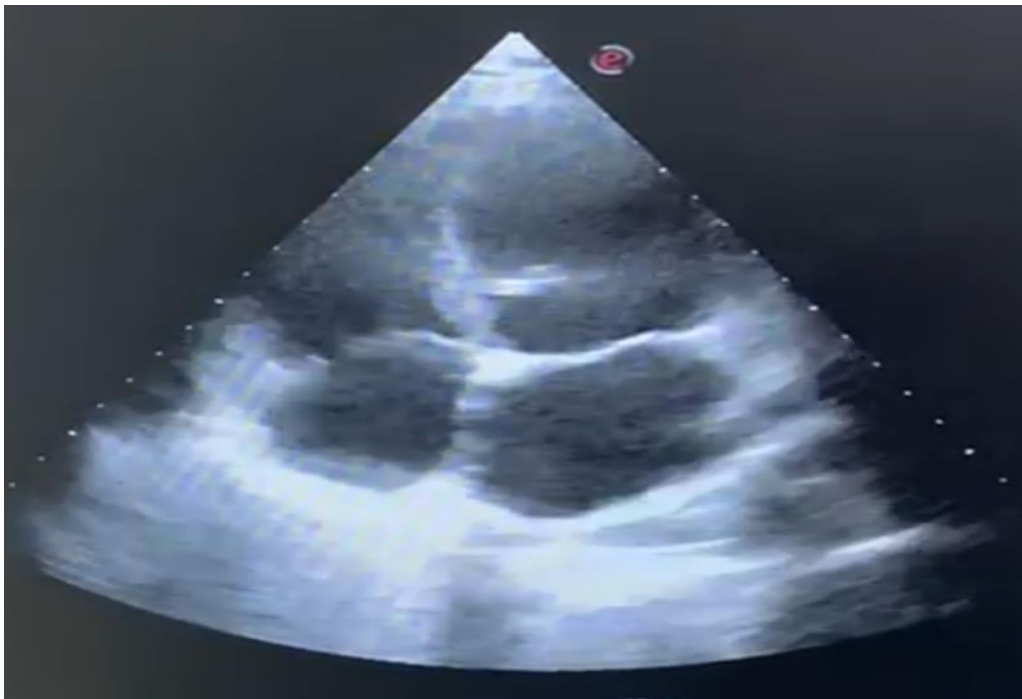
Four-chamber echocardiogram showing a dilated LV
